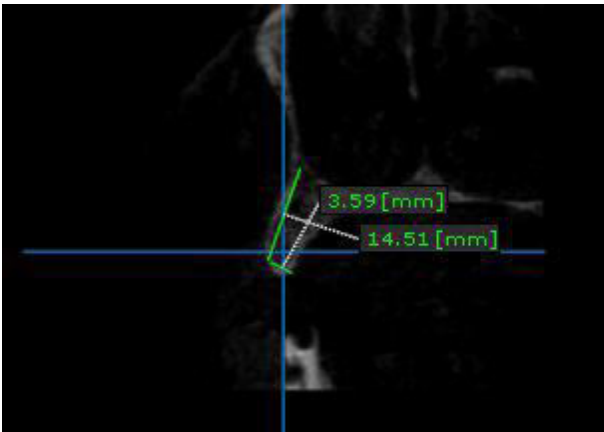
b) Saggittal Cross Section of CBCT
